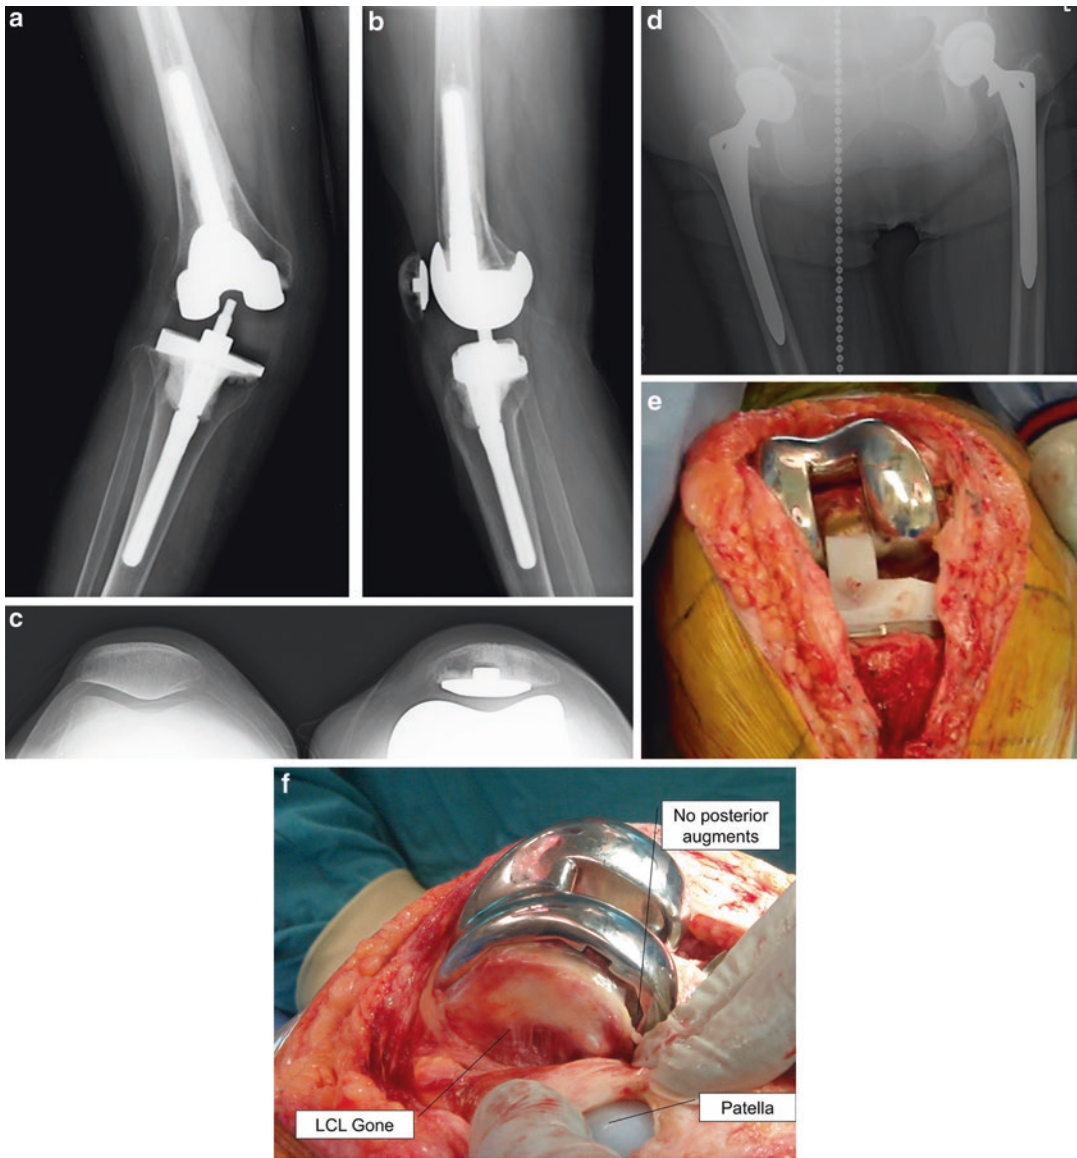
Gross instability after joint line first RevTKA. (a) Gross valgus instability of a non-linked constrained revision TKA. The primary TKA was revised for the same problem. The surgeon reestablished the distal femoral articulation using distal femoral augmentation, following a “joint line first” approach and inserted an undersized non-linked constrained device with distal but not posterior augments. When this failed, another surgeon logically performed an arthrotomy and inserted a custom fabricated angled bearing insert to decrease the valgus deforming force (seen in this radiograph). (b) Lateral radiograph. (c) Centrally tracking patella arguing in favor of good rotational position of tibia and femur. (d) Bilateral total hip arthroplasty plus scoliosis (plumb line) raise questions about the dynamics of gait. (e) At the third revision, there
